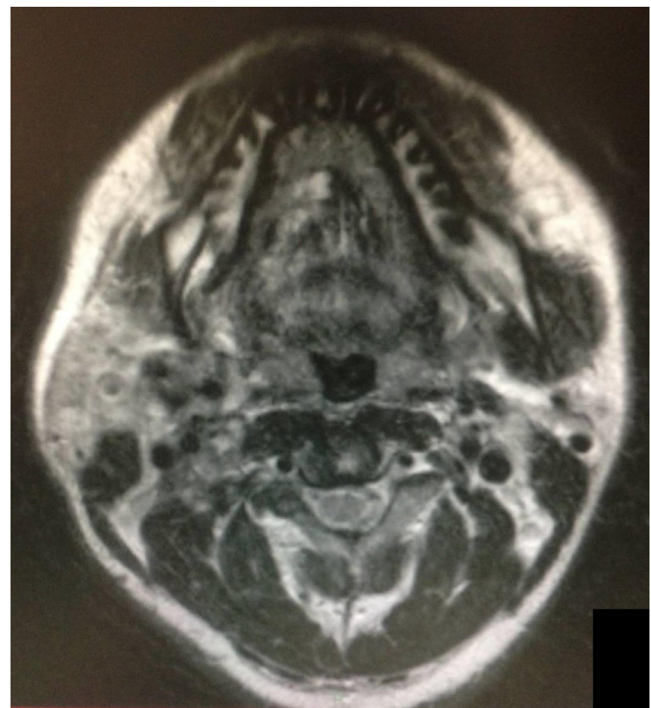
Preoperative non-contrast T2-weighted magnetic resonance imaging. Mild signal hyperintensity is evident on the right side of the tongue, and small cystic lesions are apparent in the right parotid gland.
